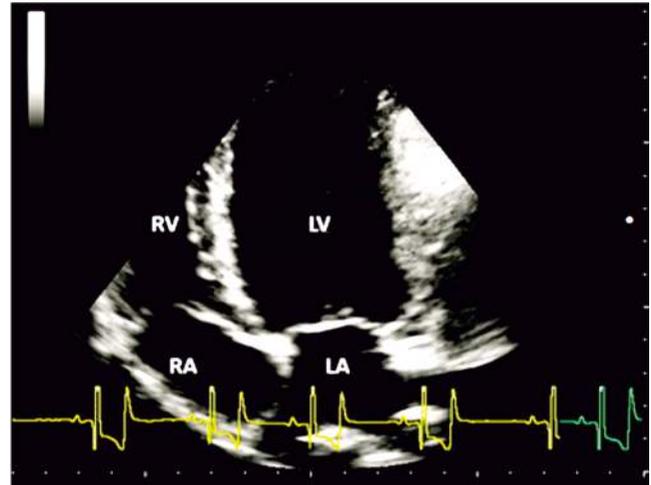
Apical four-chamber view (LA-left atrium, LV-left ventricle, RA-right atrium, RV-right ventricle)
